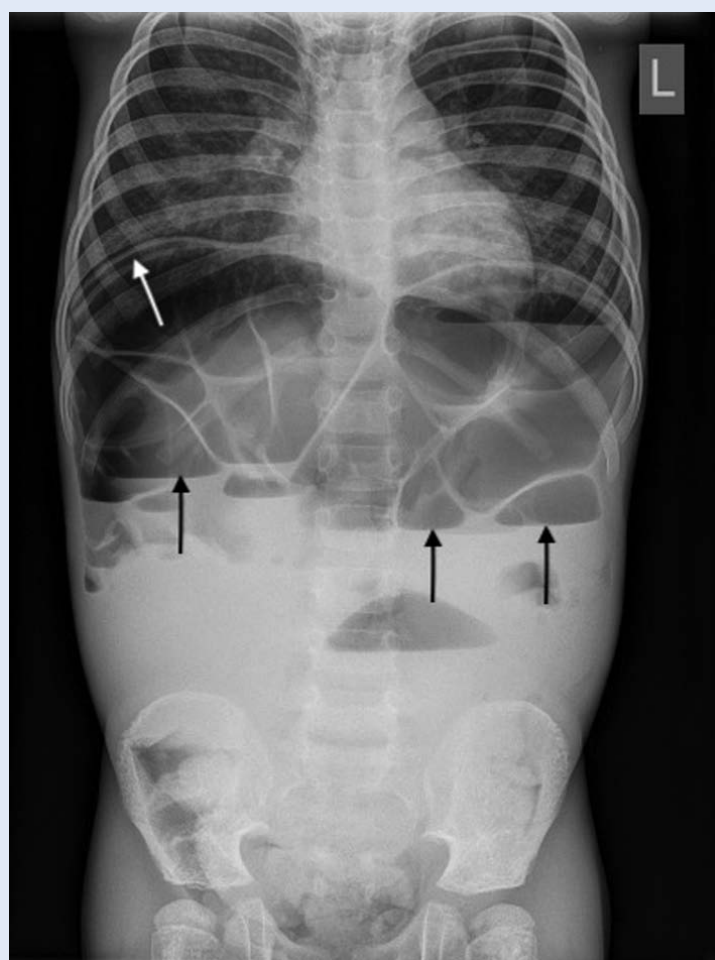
Abdominal X-ray revealing air-fluid levels (black arrow) and subdiaphragmatic sickle-shaped transparency (white arrow).
